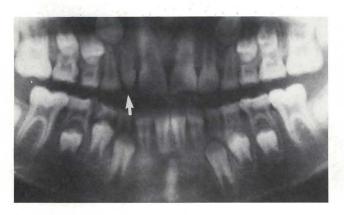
A radiograph of an eight-year-old female, with a pegshaped right maxillary lateral incisor.
